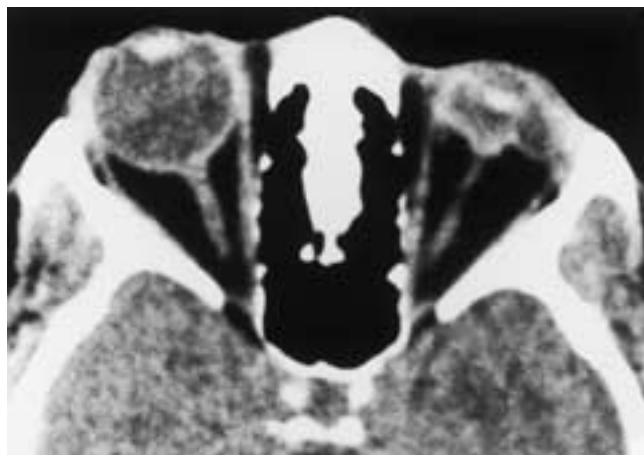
Ocular rupture. Axial CT scan shows deformity of the left eye with uveoscleral infolding due to ocular hypotony related to a rupture.
